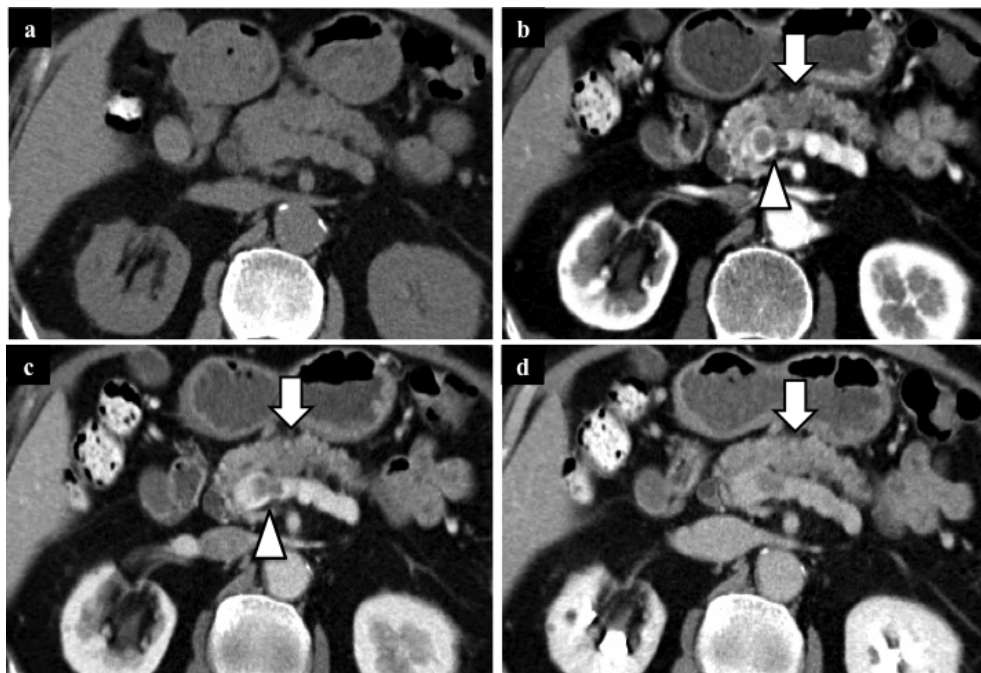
Abdominal dynamic computed tomography of the pancreas. a: plane, b: artery phase, c: portal venous phase, d: late phase. The tumor of the pancreatic body was gradually contrasted (white arrow), and a tumor thrombus-like structure was also present in the region from the splenic vein to the superior mesenteric vein (arrowhead).
